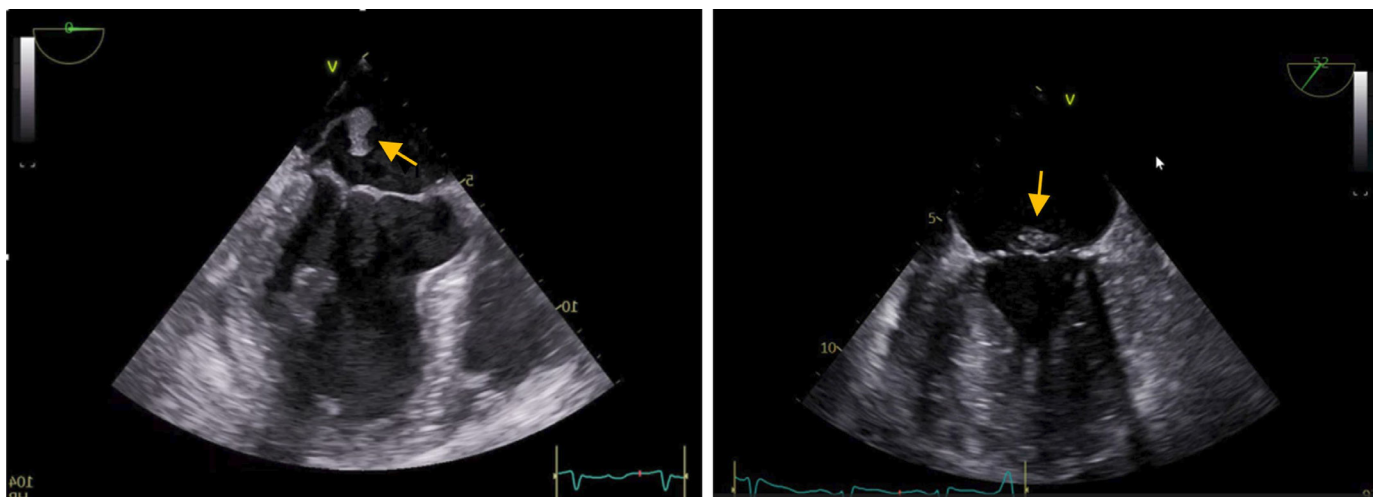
TEE vegetation on the mitral valve, with maximum length >10mm with high embolic risk (arrows). TEE, transoesophageal echocardiography.
